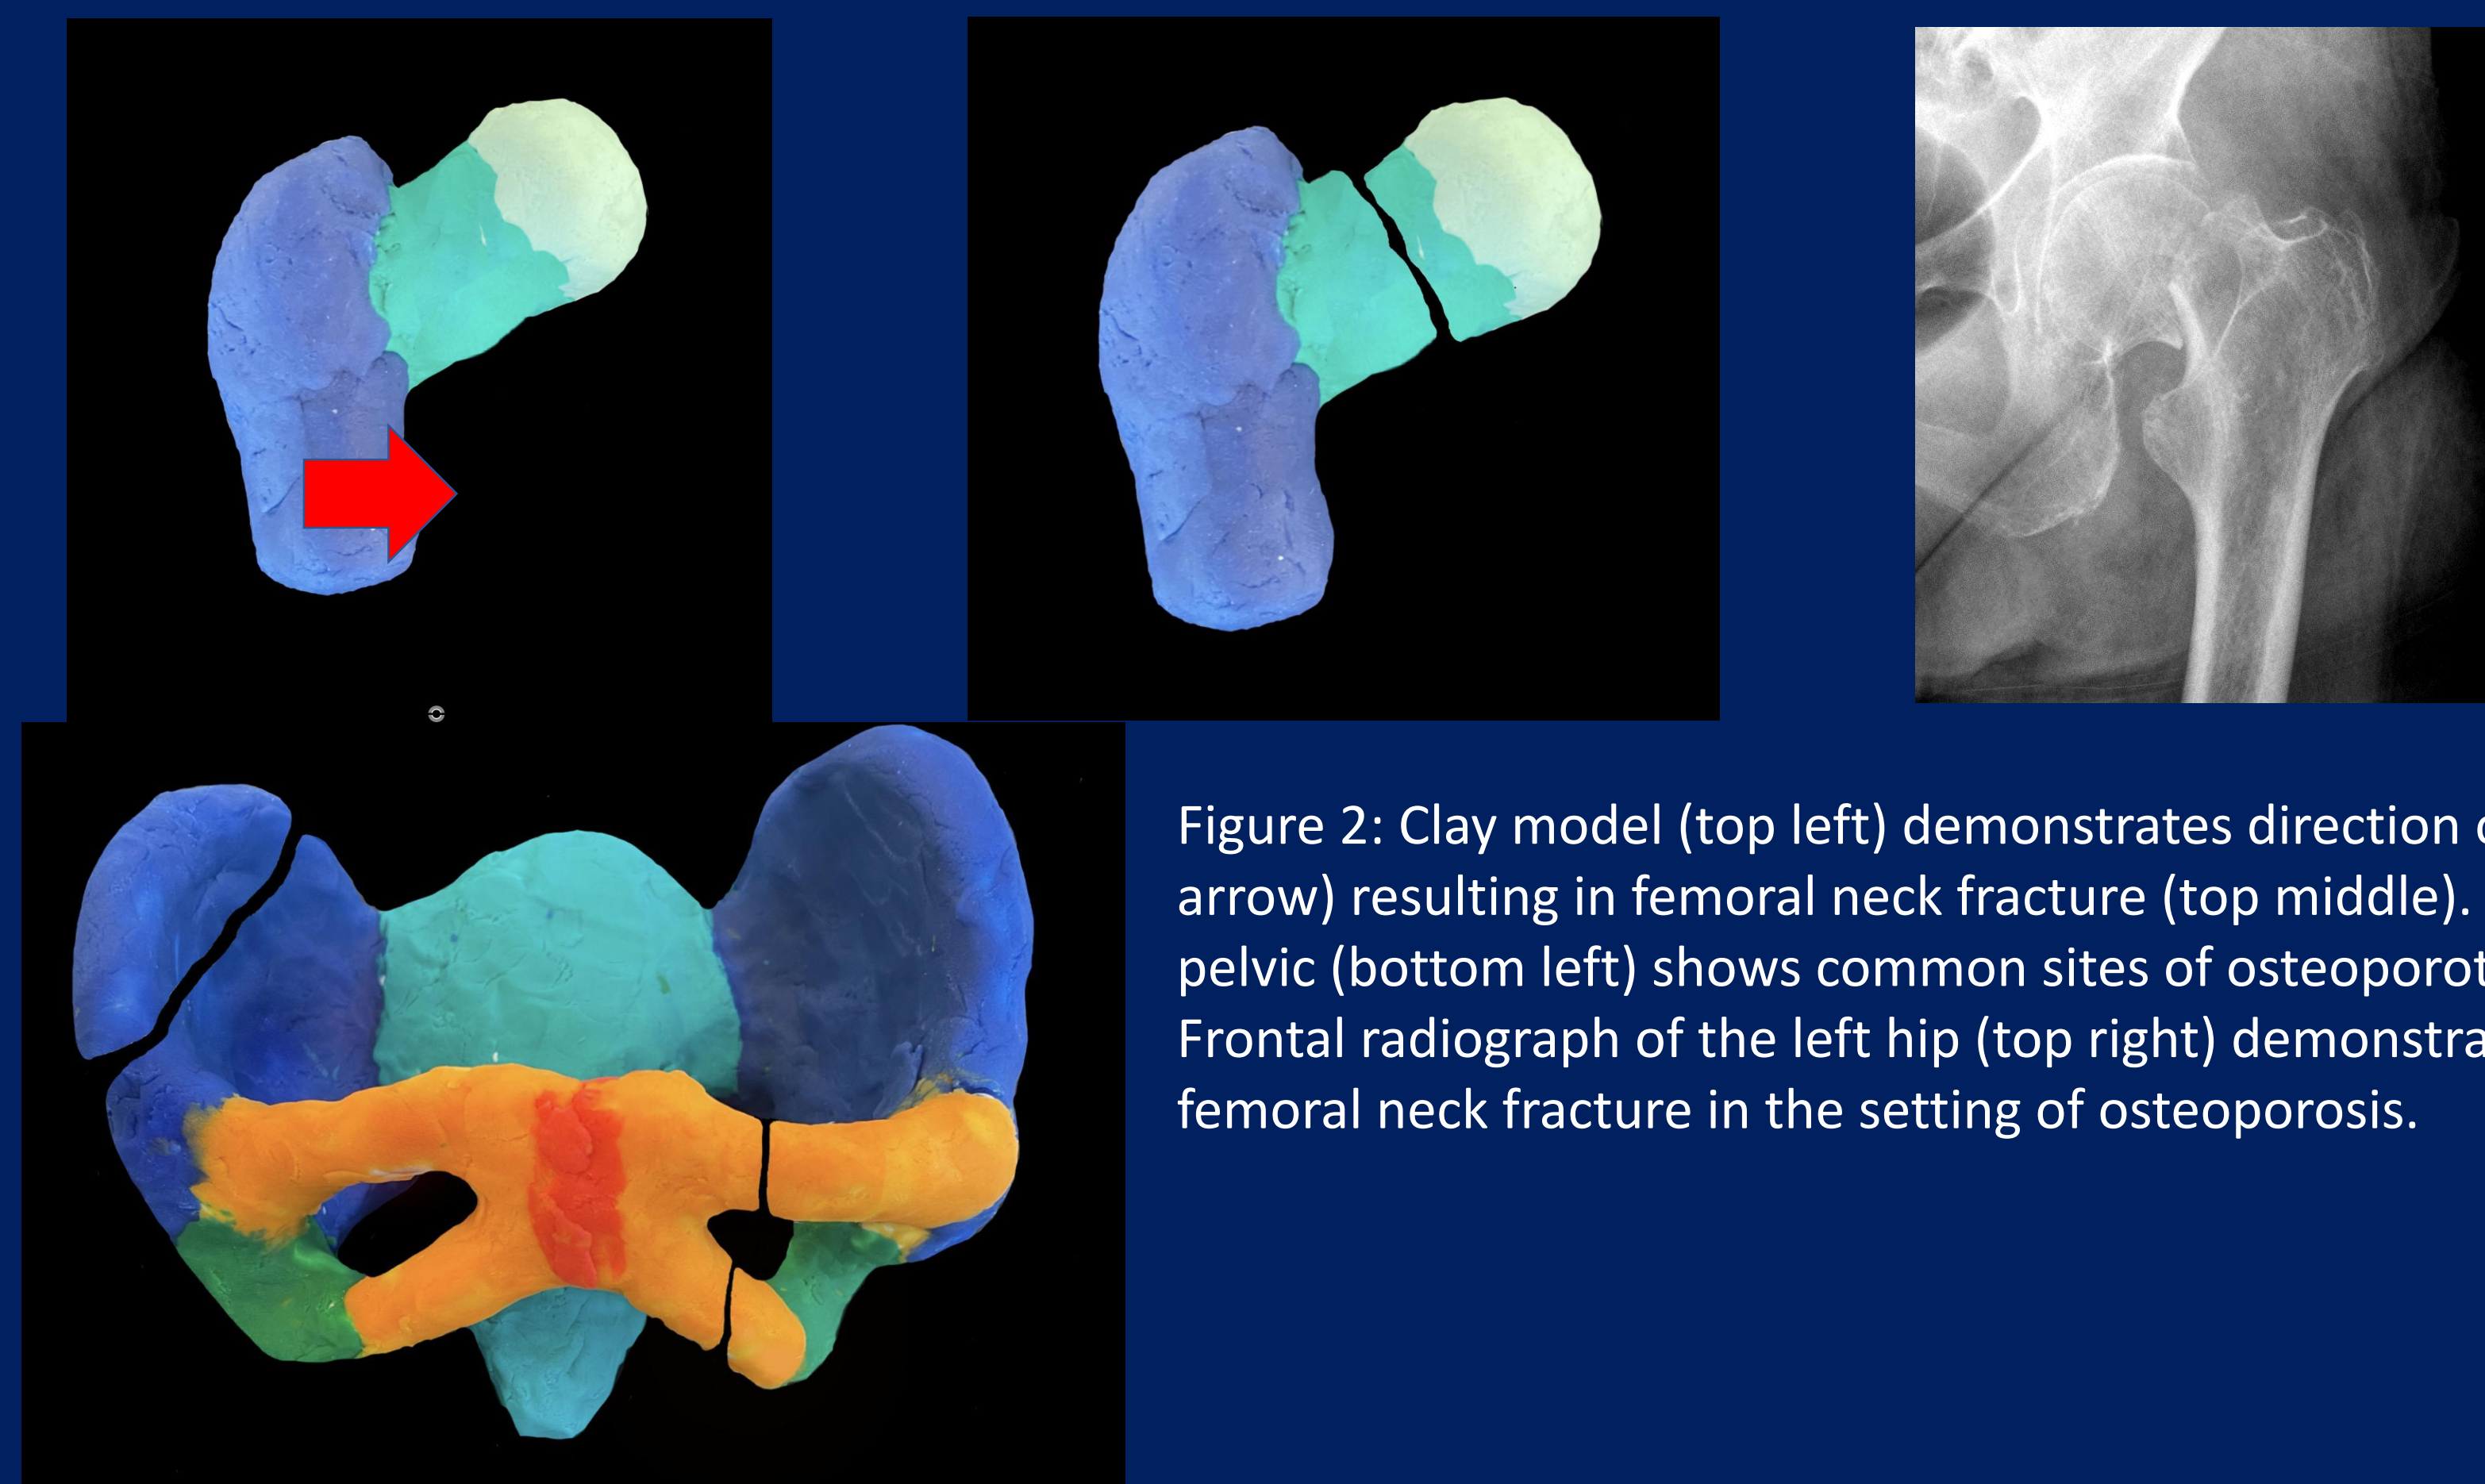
Clay model (top left) demonstrates direction of force (red arrow) resulting in femoral neck fracture (top middle). Clay model of the pelvic (bottom left) shows common sites of osteoporotic pelvic fractures. Frontal radiograph of the left hip (top right) demonstrates displaced femoral neck fracture in the setting of osteoporosis.
